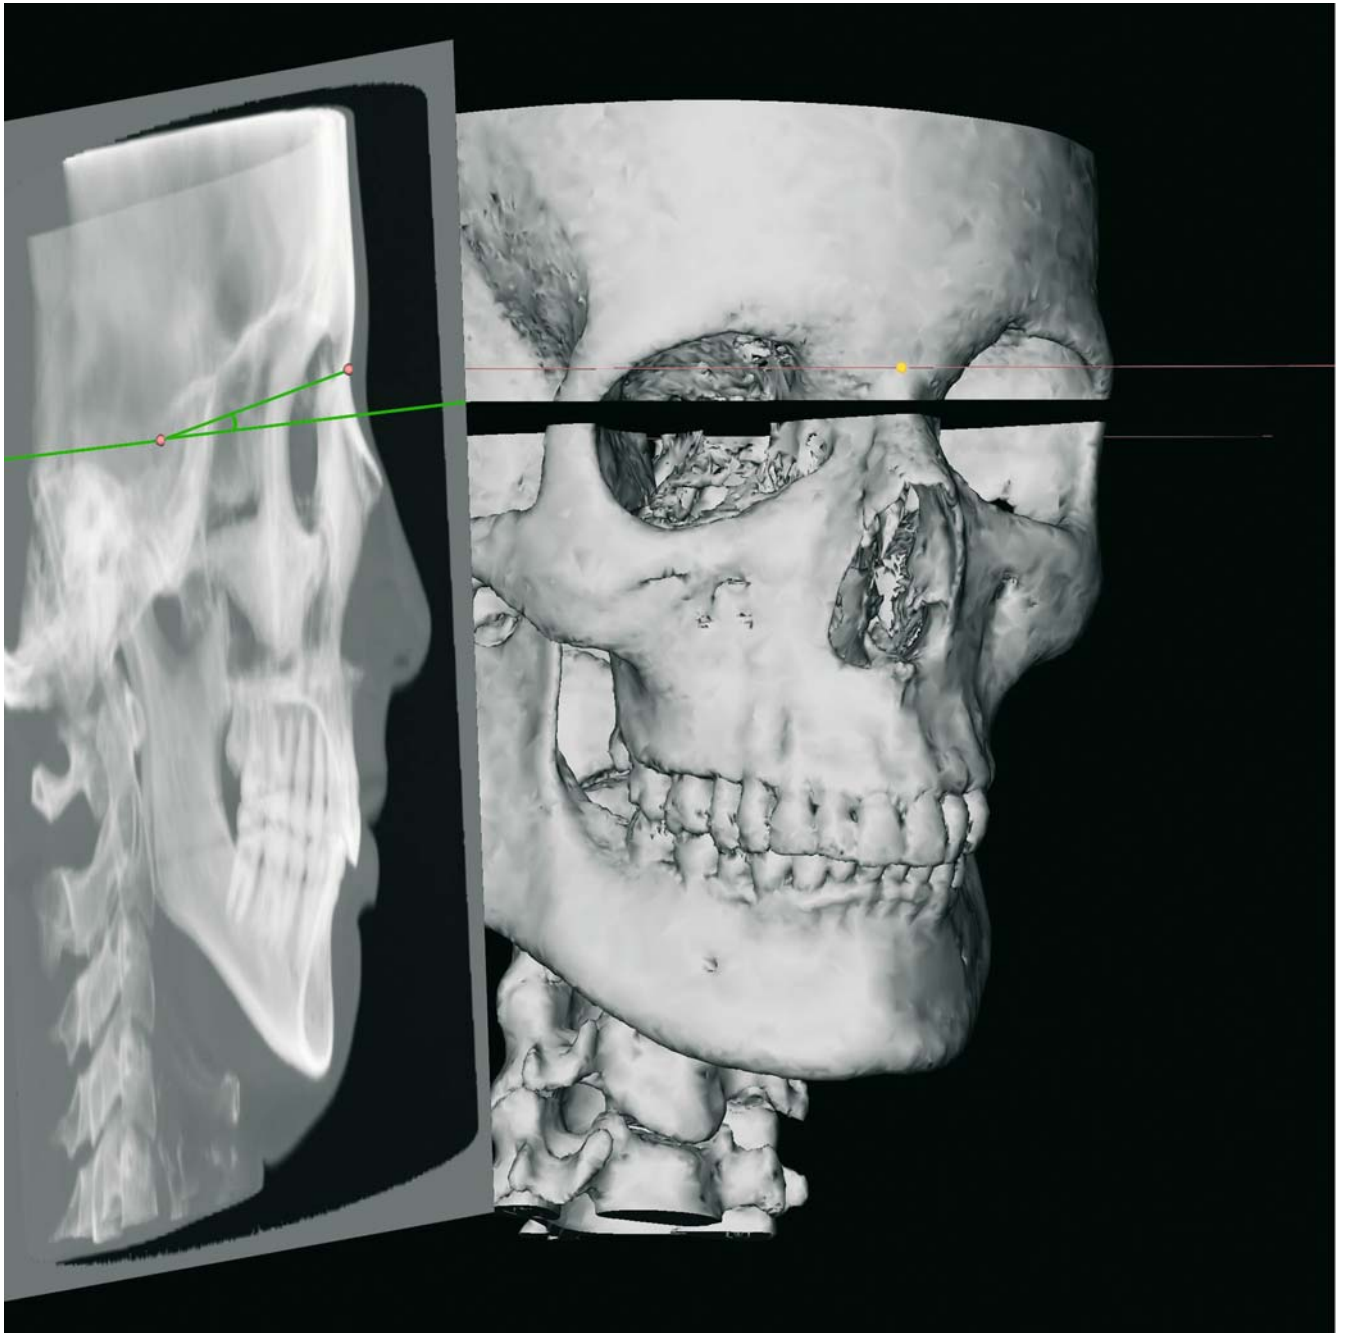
Horizontal (x) 3-D cephalometric reference plane. Virtual lateral cephalogram linked to the 3-D hard tissue surface representation (3-D CT, patient K.C.)
